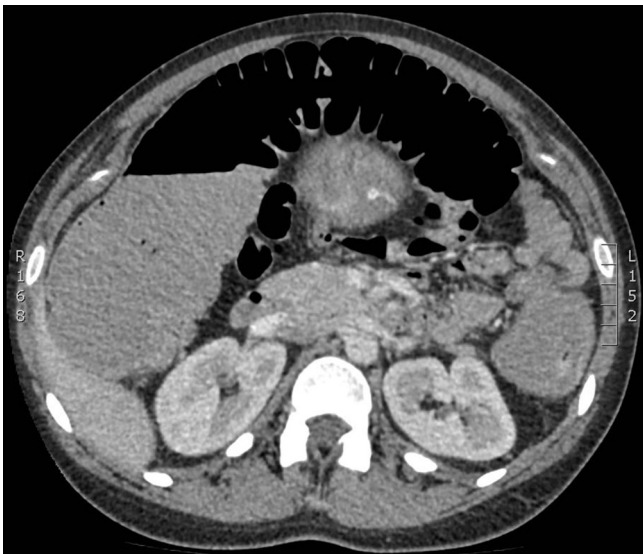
Transverse plane of abdominal CT-scan showing the lineal flexure and faecal impaction.
